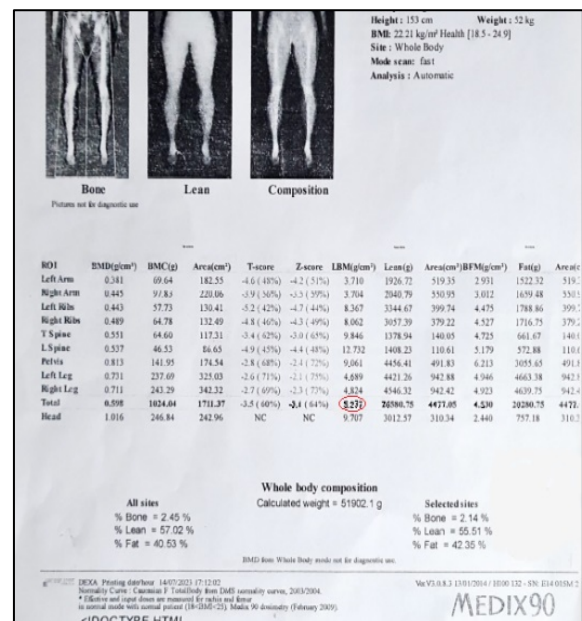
A total body dual-energy X-ray absorptiometry.
